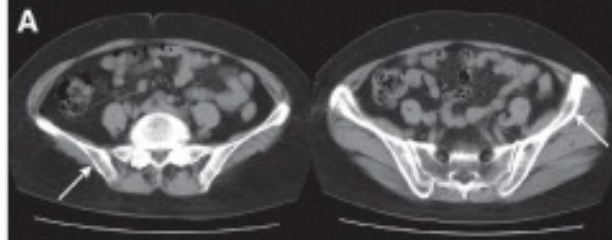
In this patient, there were multiple lung metastases besides bone metastases. (A) CT scan shows osteolytic lesions on both sides of iliac bones (arrows). (B) ^{201}Tl SPECT image
